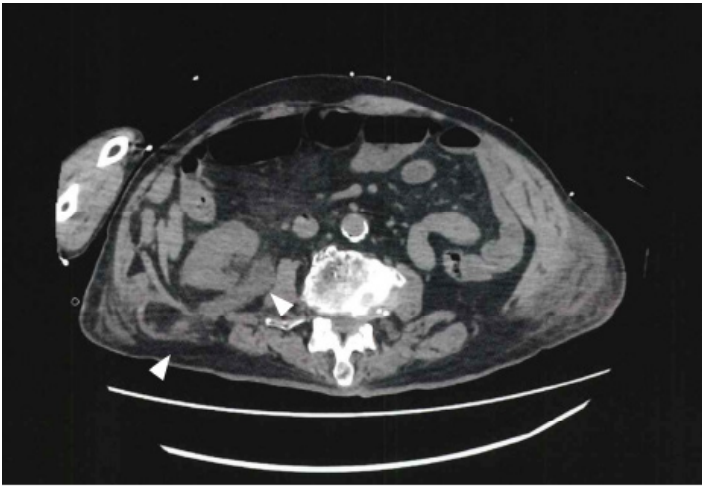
Computed tomography (axial view) caudal of Image 1, showing the dilated ureter and herniation.
